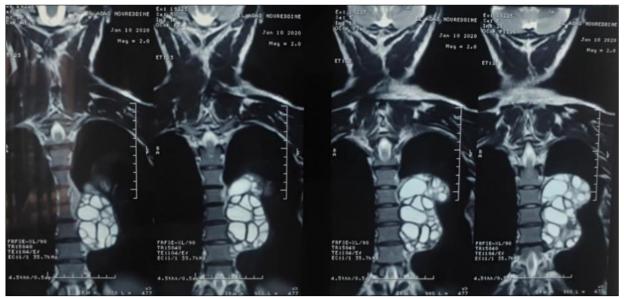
MRI Image coronal T2 weighted Signal: showing multicystic lesion in Grape in the left lung
